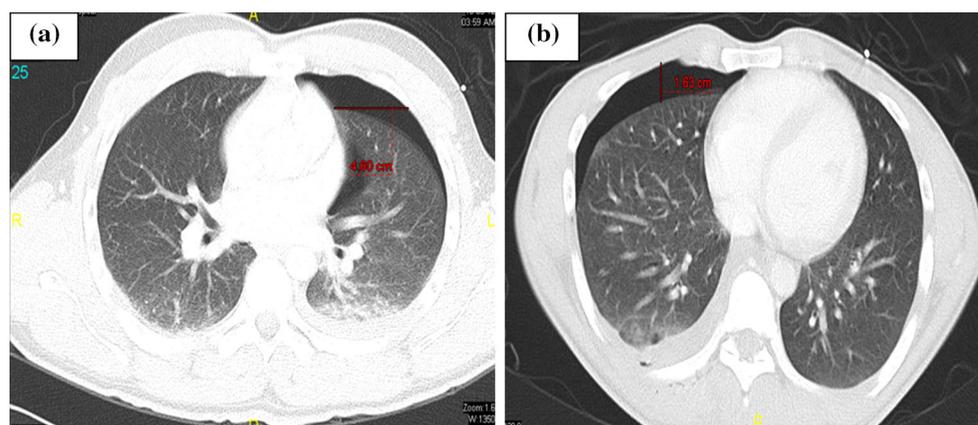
Scoring based on CT findings a the lateral air pocket of 46 mm; (Score: $46 + 20 = 66$); b The AP air pocket is 16 mm; (Score: $16 + 10 = 26$)
